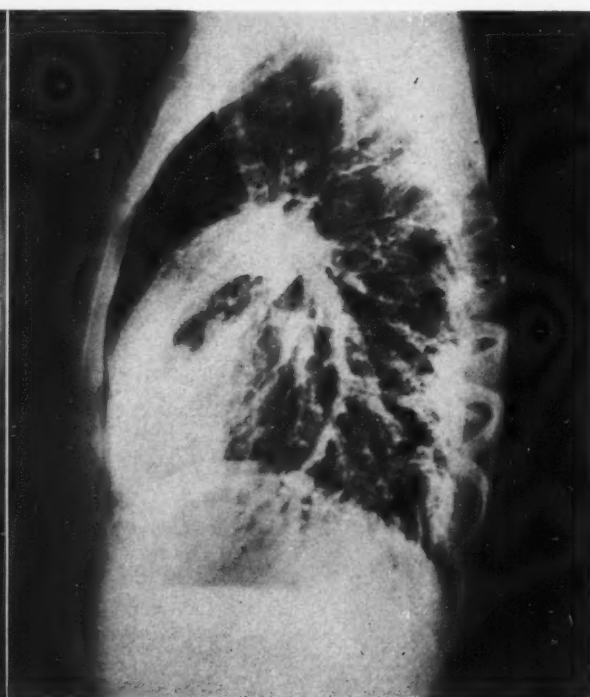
Case II. Pulmonary arteriovenous fistula, medial basilar segment, right lower lobe in a patient with rheumatic heart disease (mitral stenosis). A, conventional frontal roentgenogram showing a nest of small nodular densities just above the right diaphragm. The heart, pulmonary artery and branches are enlarged. B, serial frontal angiocardio-gram at five seconds shows a large pulmonary artery and branches. A large segmental pulmonary artery from the right descending branch of the pulmonary artery proceeds to the right lower lobe connecting with a coiled series of rounded densities (arteriovenous fistula) which in turn empty via an efferent vessel into the left atrium. C, left lateral angiocardio-gram at three seconds shows the opacified main stem pulmonary artery and branches with an afferent basilar segmental division connecting the circinate arteriovenous fistula.
